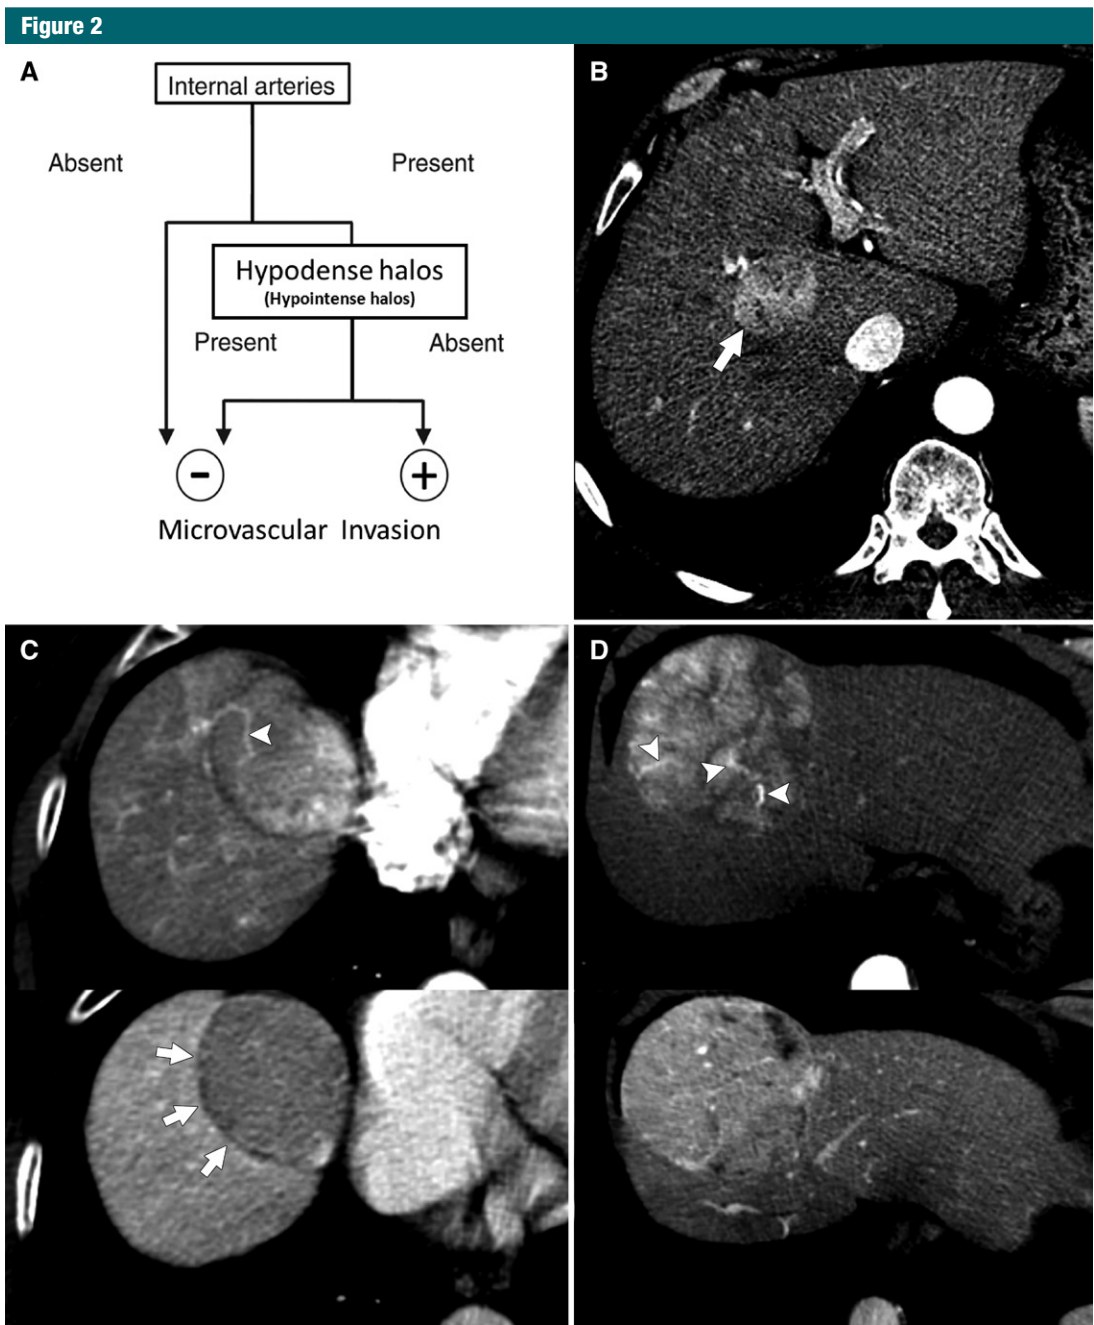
TTPVI. *A*, The two-trait algorithm predictive of MVI, modified from Segal et al (20), is based on the imaging identification of two features: internal arteries assessed in the arterial phase and hypoattenuating halos at CT (or hypointense halos at MR imaging) evaluated in the portal venous or equilibrium phases. *B–D*, Axial CT images show the three possible combinations of these two imaging features. *B*, Homogeneously hyperattenuating tumor (arrow) is seen without appreciable internal arteries, suggestive of the absence of MVI. *C*, Tumor with internal arteries (arrowhead on the upper image) and continuous hypoattenuating halos (arrows on the lower image) is indicative of the absence of MVI. *D*, Tumor with internal arteries (arrowheads on the upper image) and noncontinuous hypoattenuating halos (lower image) is suggestive of MVI.
